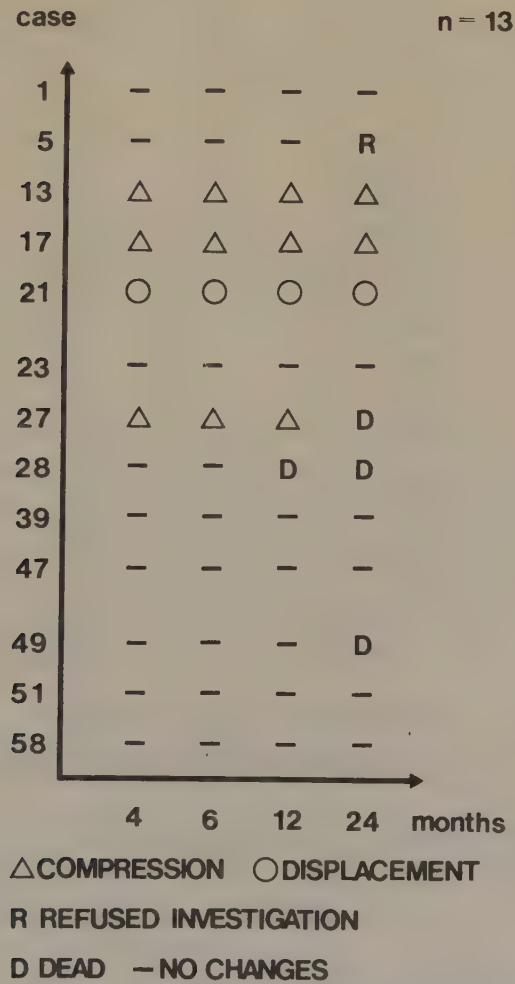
Radiographic changes in the femoral neck in 13 cases with uncomplicated healing
